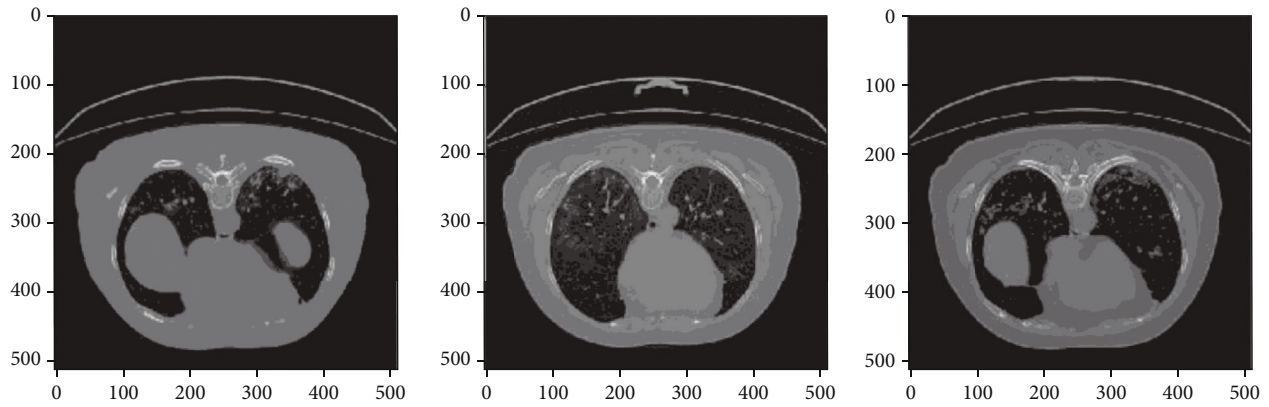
Colormap for COVID-19-affected chest CT scan images correctly classified by AlexNet+SVM and AlexNet+Random Forest.
